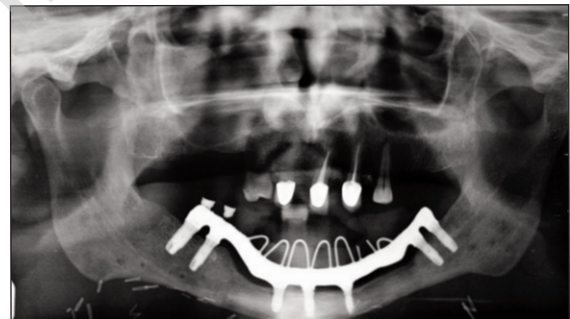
Orthopantomography follow up.
